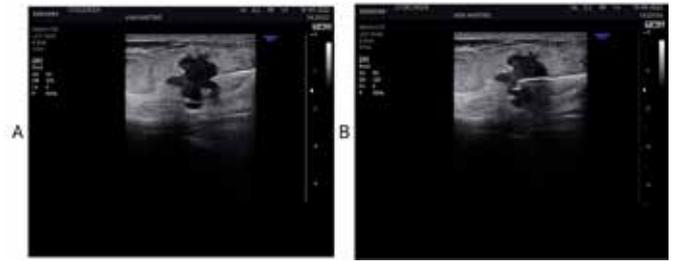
Core biopsy ultrasound. BI-RADS Node 5. A. Needle positioned before firing. B. Needle positioned after shooting.
